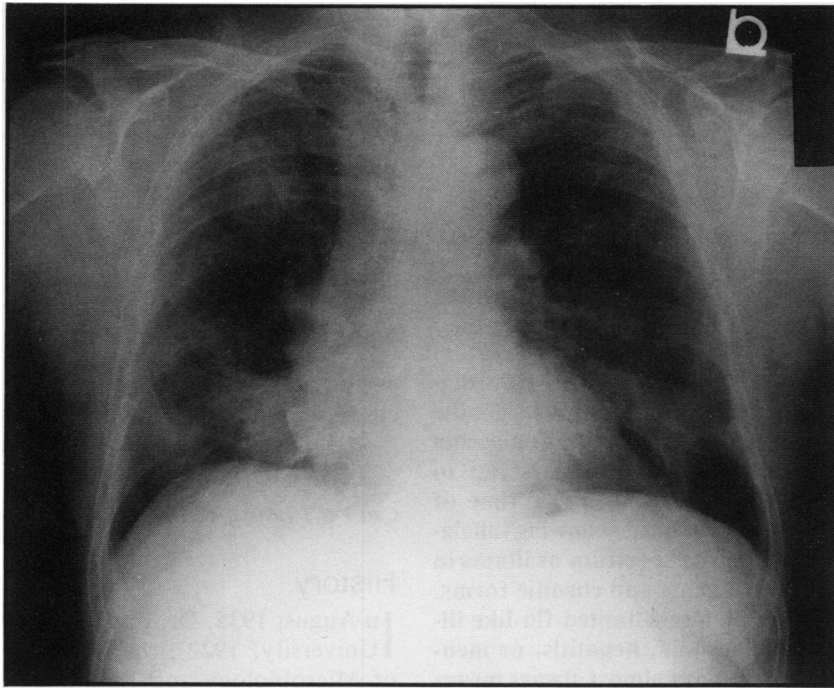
Chest radiograph of a patient with Q fever pneumonia. Note three opacities in the right lung and two in the left.
